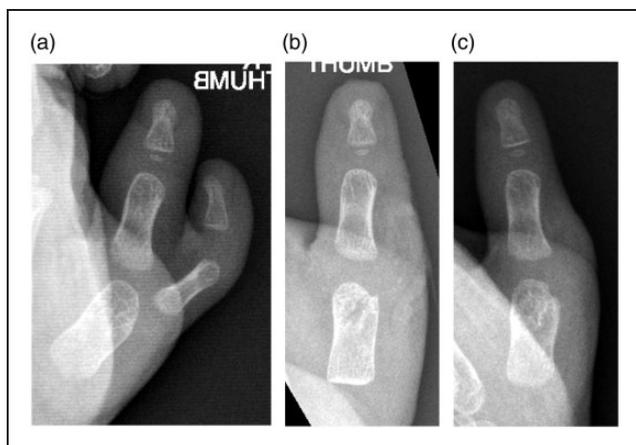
Radiographs of child undergoing an oblique closing wedge osteotomy. (a) Preoperative. (b) One week after operation. (c) Six weeks after operation showing bony union.
